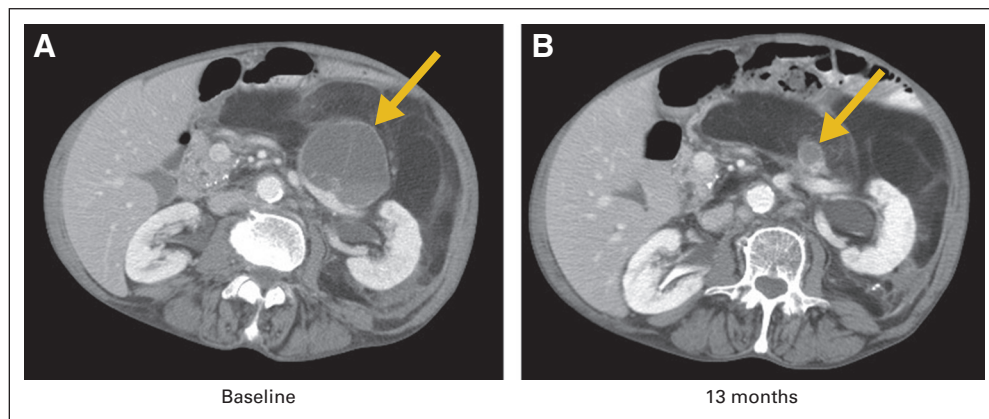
Computed tomography scans at (A) baseline and (B) after 13 months of treatment with PD0332991, demonstrating favorable tumor response (arrows) in dedifferentiated liposarcoma surrounded by well-differentiated liposarcoma.
